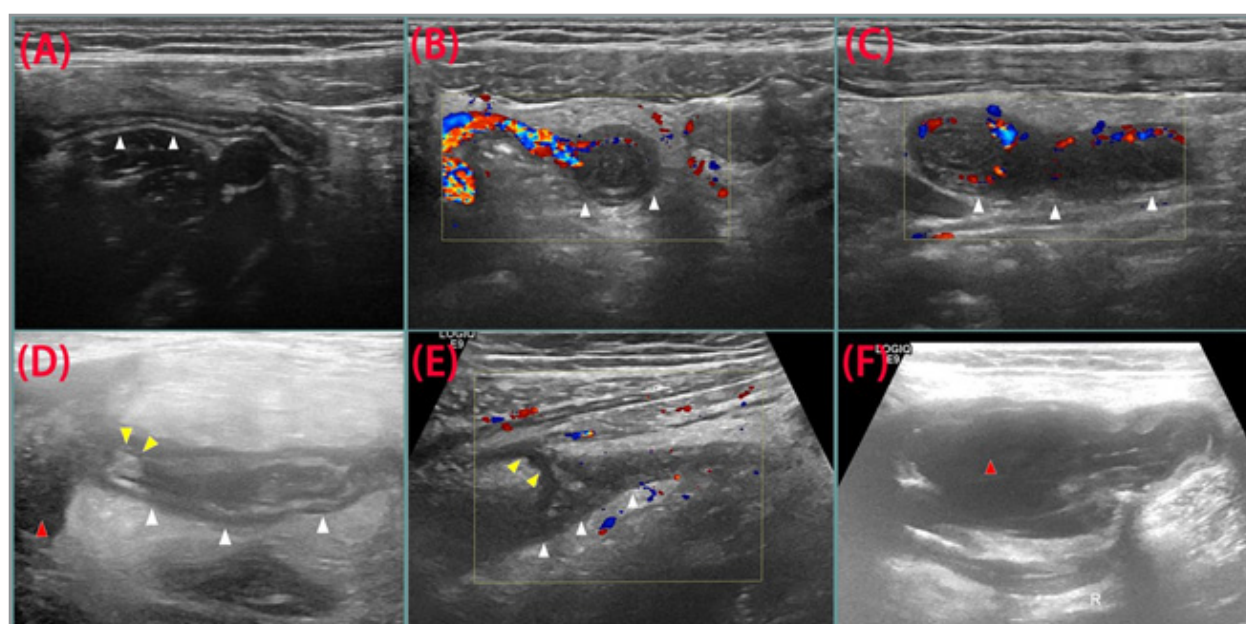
Ultrasonographic manifestations of various types of acute appendicitis
